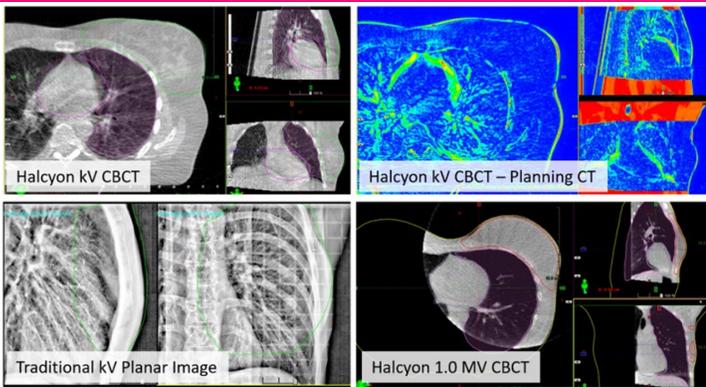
Example of Halcyon kV CBCT, MV CBCT, and traditional kV planar image for breast treatment image guidance. Image from *Cureus* 10(10): e3510. doi:10.7759/cureus.3510. Used under CC-BY license.
